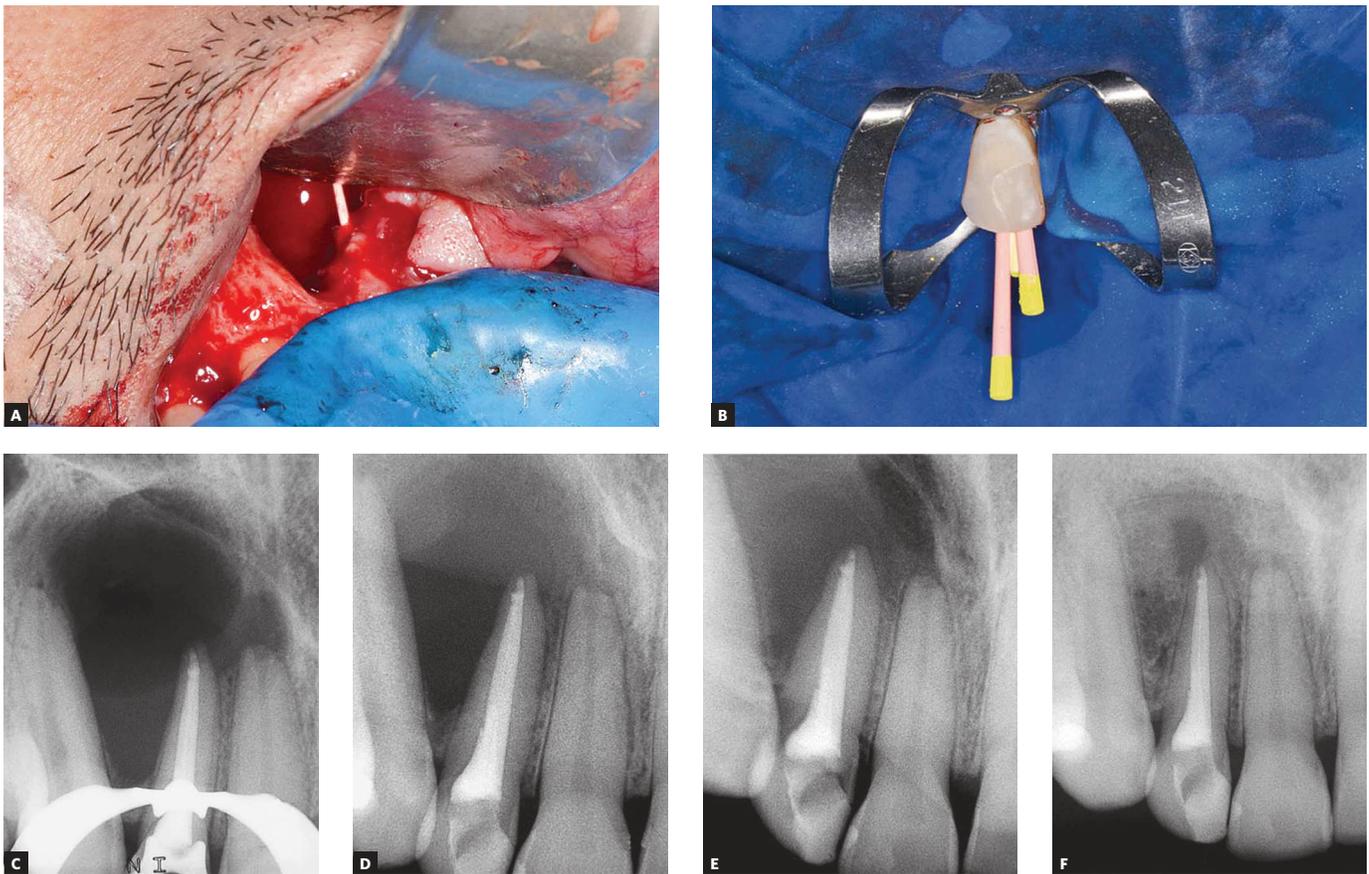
A) Master gutta-percha point beyond root apex. B) Gutta-percha lateral condensation. C) Root canal filling immediate final radiograph. D) Radiographic image after one-week. E) Radiographic image after 3 months. F) Radiographic image after 6 months.
